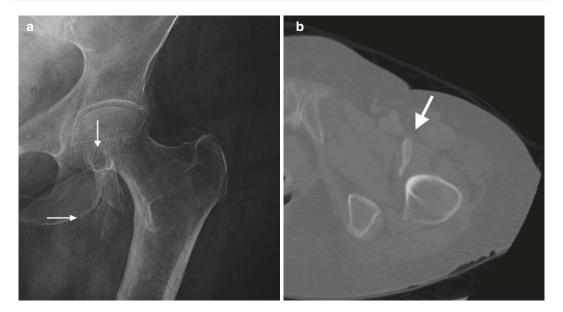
Posttraumatic heterotopic ossification of the left iliopsoas in an 81-year-old female on (a) radiograph (*arrows*) and (b) CT (bone windows)
